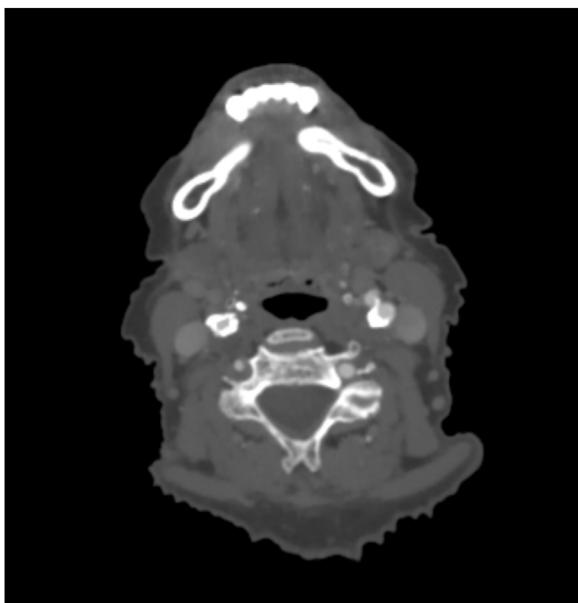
Axial section from computed tomography demonstrating atherosclerotic disease at the distal common carotid artery bilaterally.
